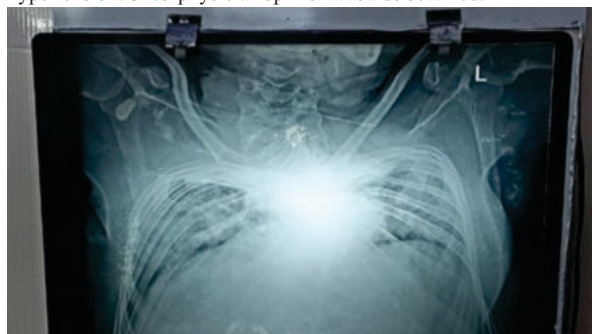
Preoperative Chest Xray:
